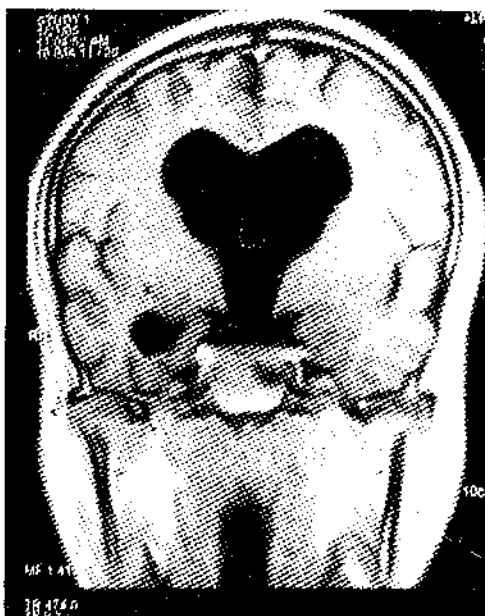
CT scan image of patient with hydrocephalus
